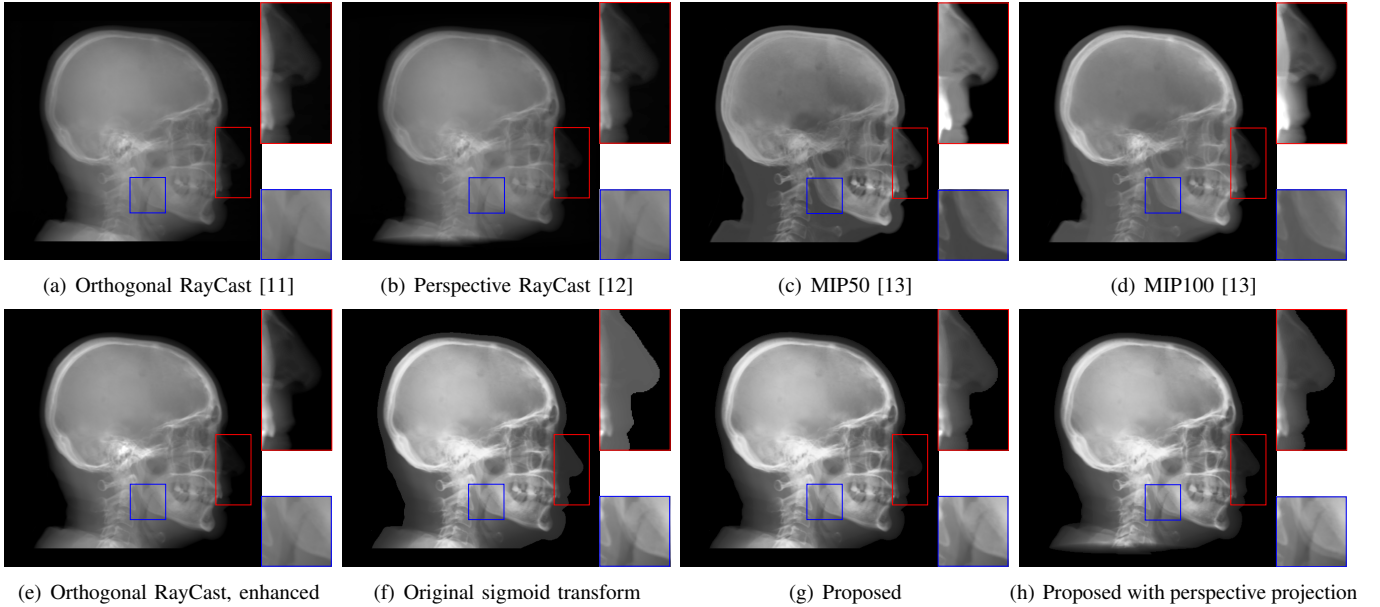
Synthetic cephalogram examples from 3D CBCT volumes with different methods. (a)-(d) are comparison results while (e)-(h) are the (intermediate) results of our proposed method: (a) RayCast using orthogonal projection; (b) RayCast using perspective projection; (c) MIP using the largest 50 pixels along each orthogonal ray; (d) MIP using the largest 100 pixels along each orthogonal ray; (e) RayCast using orthogonal projection from the skeleton enhanced volume; (f) original sigmoid transform of (e) using Eqn. (4) with air background recovery; (g) modified sigmoid transform of (e) using Eqn. (6), the final Type I synthetic cephalogram using orthogonal projection; (h) final Type I synthetic cephalogram using perspective projection. The nose ROIs are redisplayed in the intensity window $[0, 125]$ for better visualization. The mandible angle ROIs are for the visualization of the difference between orthogonal projection and perspective projection.
